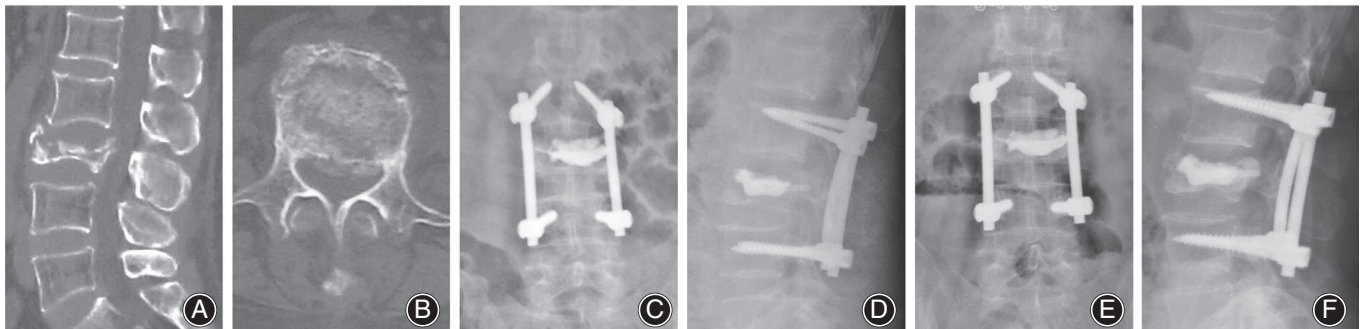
A 58-year-old male patient who underwent percutaneous fixation combined with vertebroplasty for L₃ Kümmell disease. (A, B) Preoperative CT scan showing L₃ fracture with IVC. (C, D) Postoperative X-ray showed fine bone cement position and Kümmell disease vertebral body height recovery. (E, F) Final follow-up X-rays revealing good internal fixation and bone cement position.
